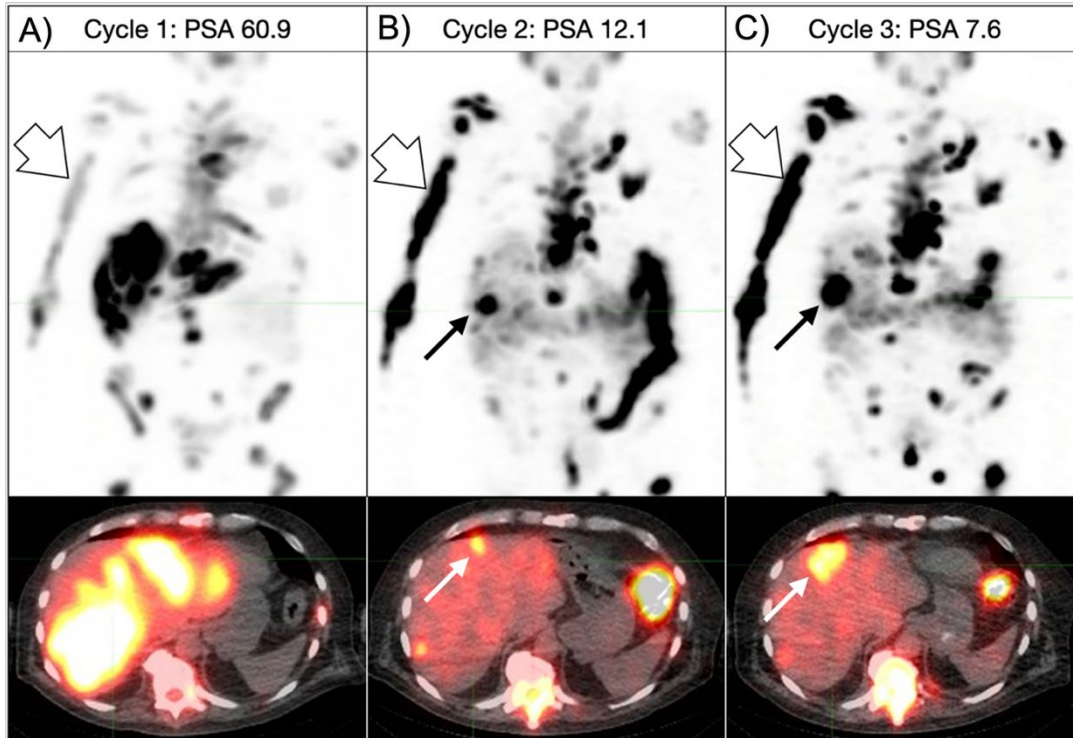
Post-treatment  $^{177}\text{Lu}$  PSMA SPECT/CT images obtained at 96 hours post-injection demonstrating heterogeneous treatment response across three cycles of radioligand therapy. A) Post-treatment SPECT at cycle 1 shows widespread disease in the liver and bones (open arrow). B) after cycle 2, there is a marked response in hepatic lesions (black arrow), while osseous disease increases (open arrow), despite a substantial decline in PSA (from 60.9 to 12.1 ng/ml). C) By cycle 3, there is further progression in both liver and bone lesions (black and open arrows, respectively), even as PSA continues to decline (to 7.6 ng/ml). This example highlights the discordance between PSA trends and lesion-level response, reinforcing the added value of post-treatment imaging in capturing spatial heterogeneity in treatment response.
